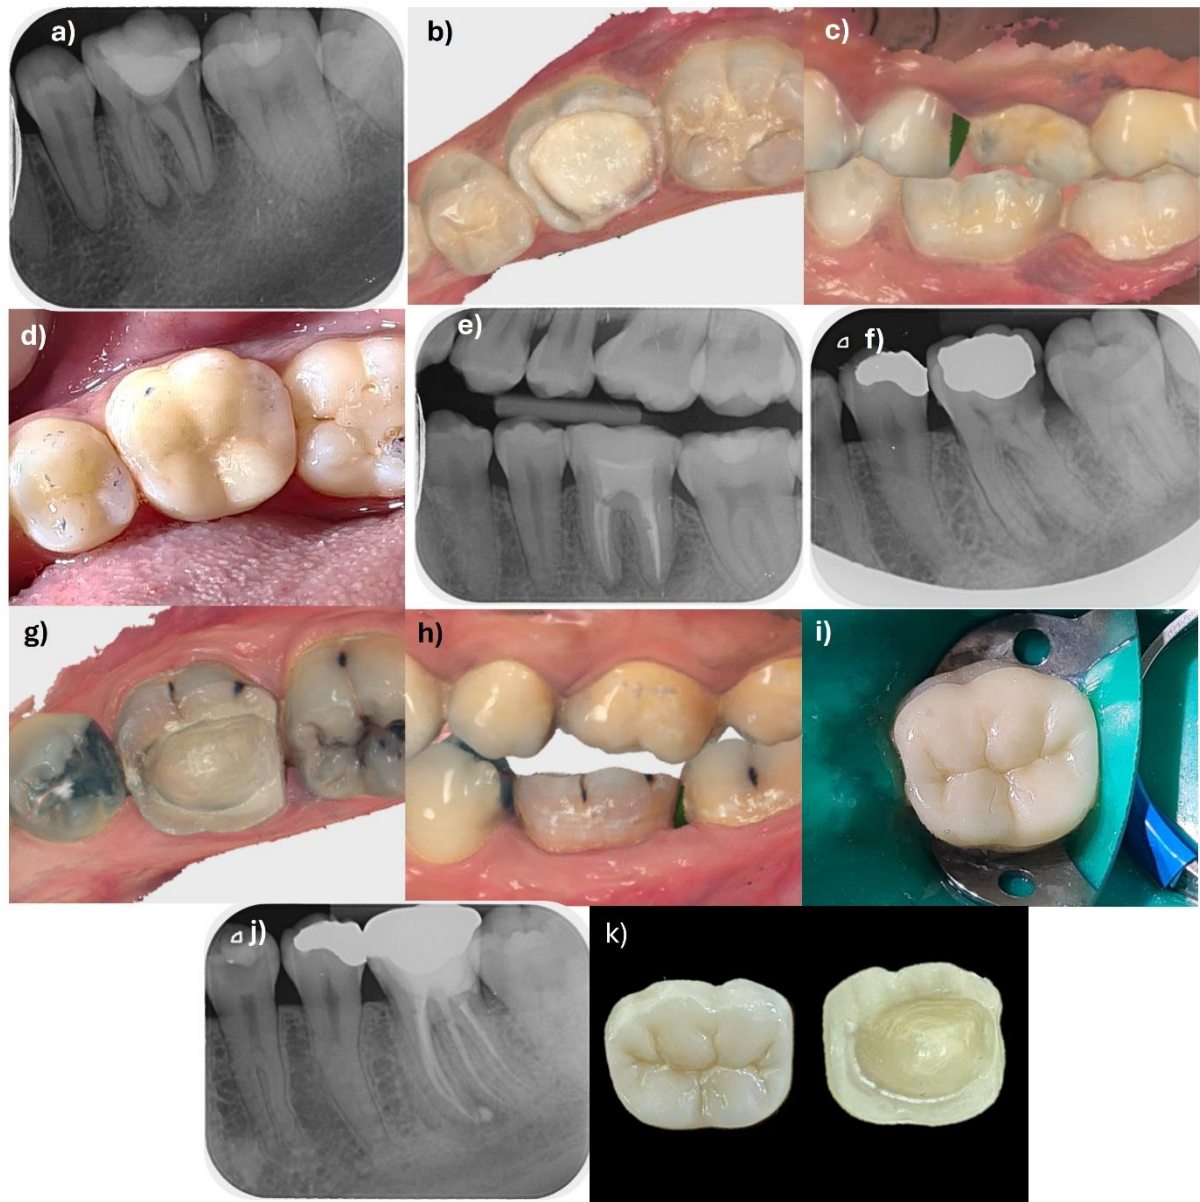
Clinical cases showing distinctions between onlay restoration and endo-overlay with DME on ETT. Case 1: (a) pre-operative radiograph of tooth 36. (b) intra-oral scanned image of tooth 36 after completion of endodontic treatment prepared for onlay (occlusal view); (c) buccal view showing no cuspal reduction, consistent with onlay design; (d) cementation of lithium disilicate onlay; and (e) post-cementation radiograph. Case 2: (f) pre-operative radiograph of tooth 36 showing deep caries margin on distal (g) intra-oral scanned image of tooth 36 after completion of endodontic treatment prepared for endo-overlay (occlusal view) with DME on distal; (h) buccal view of tooth 36 showing occlusal reduction for full cuspal coverage; (i) cementation of zirconia endo-overlay under rubber dam, (j) post-cementation radiograph showed good adaptation of overlay with the DME, and (k) endo-overlay design with 90-degree butt-joint margin limited to coronal 2mm
